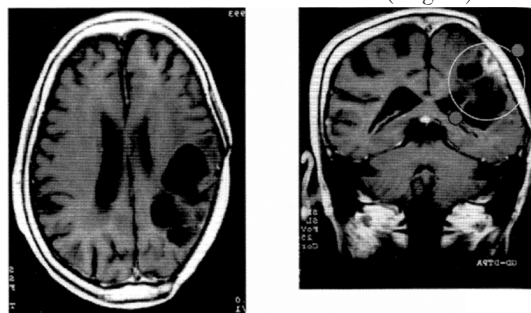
(d) Follow up CT scan 15 years after BNCT. The patient had good QOL for more than 20 years
